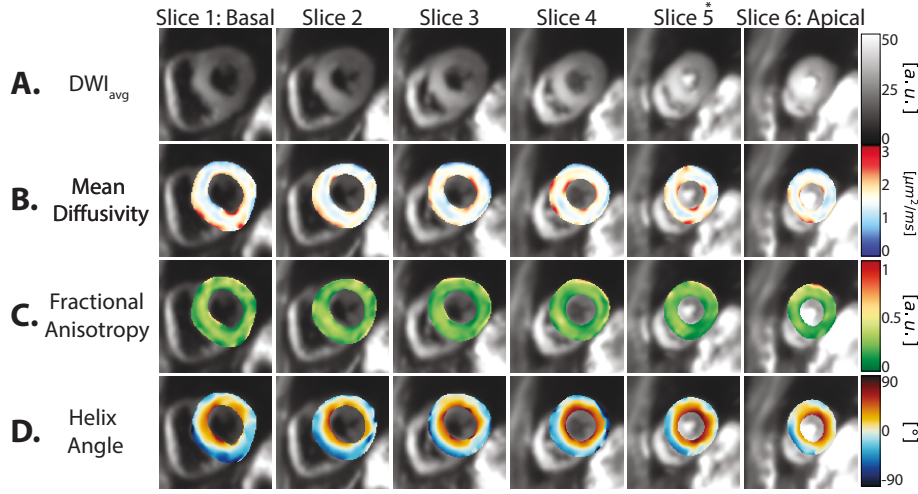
Full left ventricular cDTI coverage demonstrated in a 40yo male subject. Images show the average DWI (DWI_{avg}) (A), MD (B), FA (C), and HA (D) maps with columns indicating the slice number and position (basal, mid-ventricular, and apical). Consistent image quality was observed across the acquired slices.
